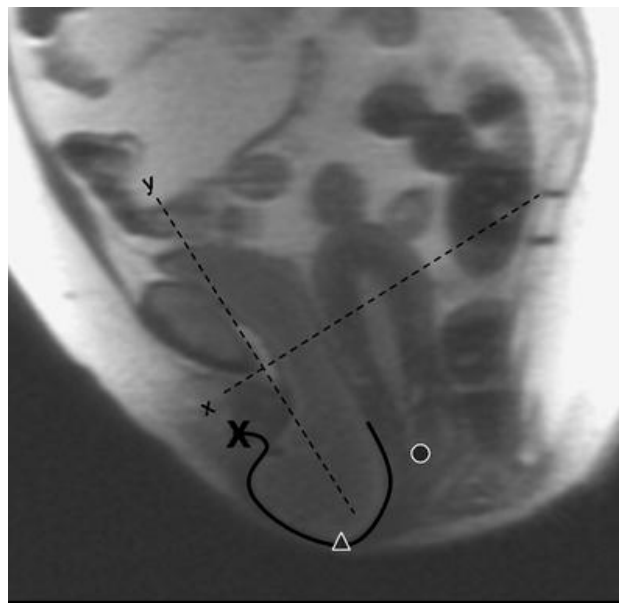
MR image at maximal Valsalva showing anterior vaginal wall tracing (solid black line), distal vaginal wall (x), bladder location (triangle), cervical os location (circle), and coordinate system (dotted lines)
